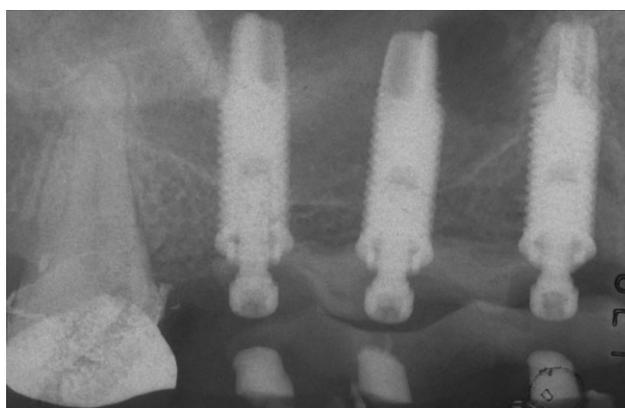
Intraoral X-ray performed immediately after surgery (baseline).
